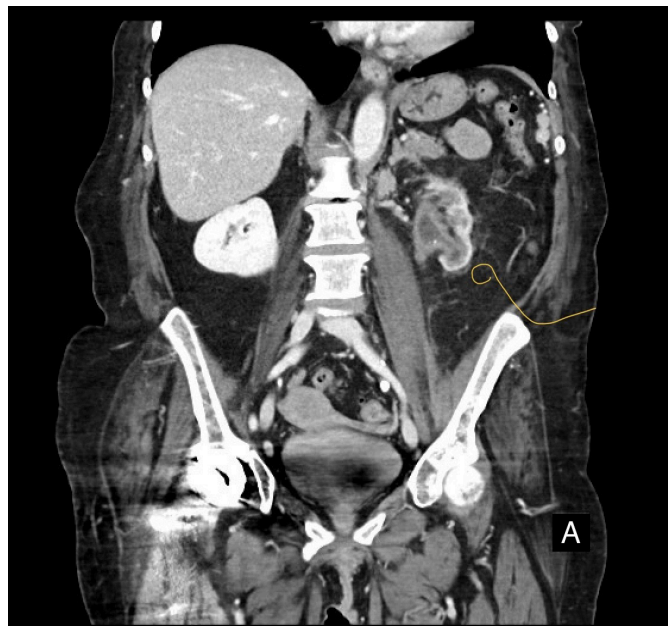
CT Abdomen Pelvis with IV contrast, coronal image, showing characteristic findings of XGP kidney including chronically obstructive nephrolithiasis with dilated renal calyces and thin parenchyma as well as perinephric fat stranding.
